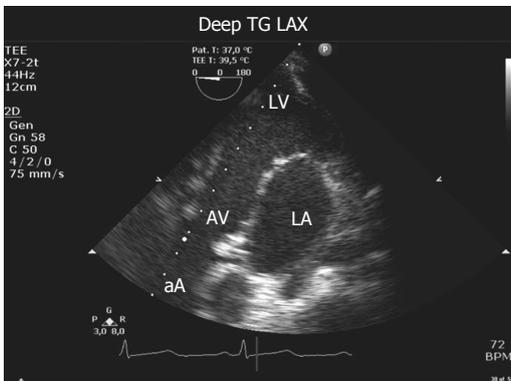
Transoesophageal echocardiography view (deep transgastric long axis view), used to measure velocity time integral. AV: Aortic valve; LA: Left atrium; LV: Left ventricle; aA: Ascending aorta; TG LAX: Transgastric long axis view. Modified by Møller-Sørensen *et al.*^[45].
